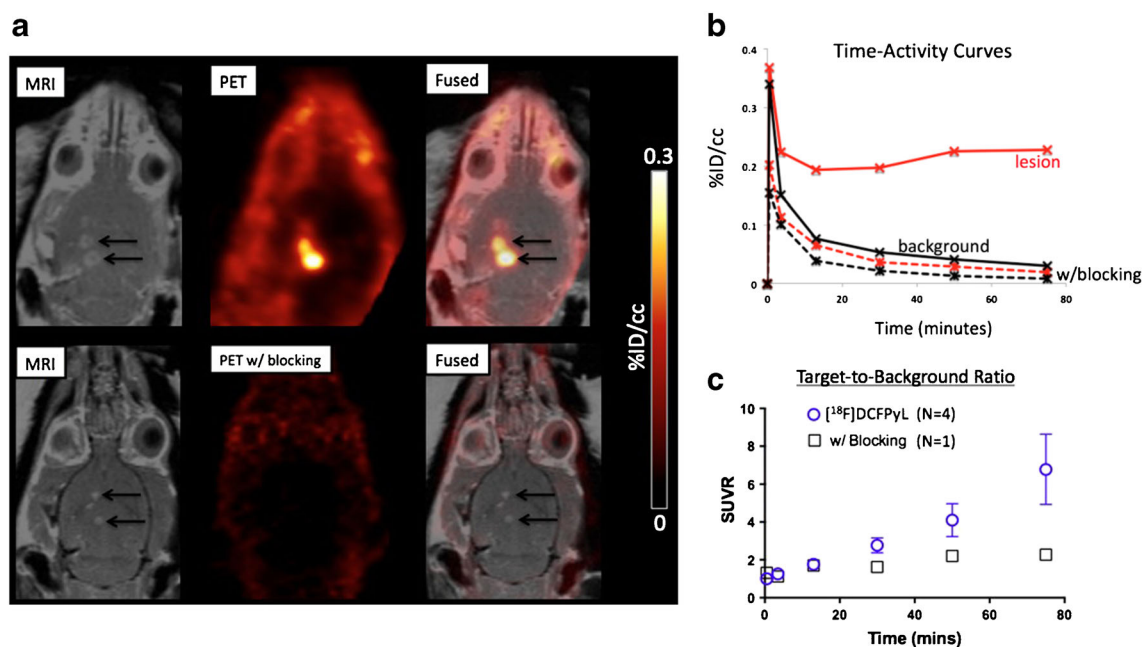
Delivery of [¹⁸F]DCFPyL to the CNS. a Coronal T1-weighted post-contrast MRI (left), PET (middle), and PET-MRI overlay (right) demonstrate delivery of [¹⁸F]DCFPyL alone (top row) or with ZJ-43 (bottom row), a competitor for GCPII binding, to the targets of BBB opening. b Time-activity curves for PET-CT imaging of [¹⁸F]DCFPyL alone (solid curves) or with the blocking agent ZJ-43 (dashed curves) delivered to BBB opening targets (red curves) vs. background regions of interest (black curves). c SUV ratios (SUVr) of target to background vs. time for PET-CT imaging following MRgFUS BBB opening and administration of [¹⁸F]DCFPyL alone (blue circles; presented as mean \pm standard deviation) or with the blocking agent ZJ-43 (black squares) (Color figure online).
